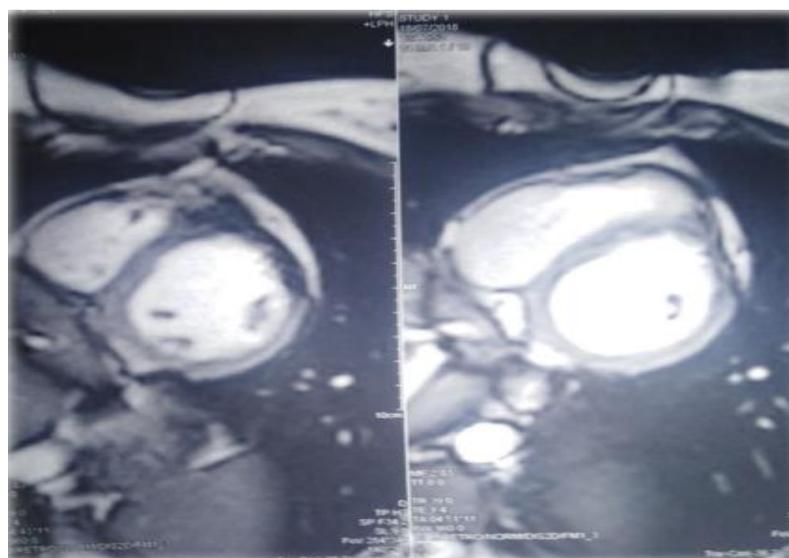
MRI image of the same patient
